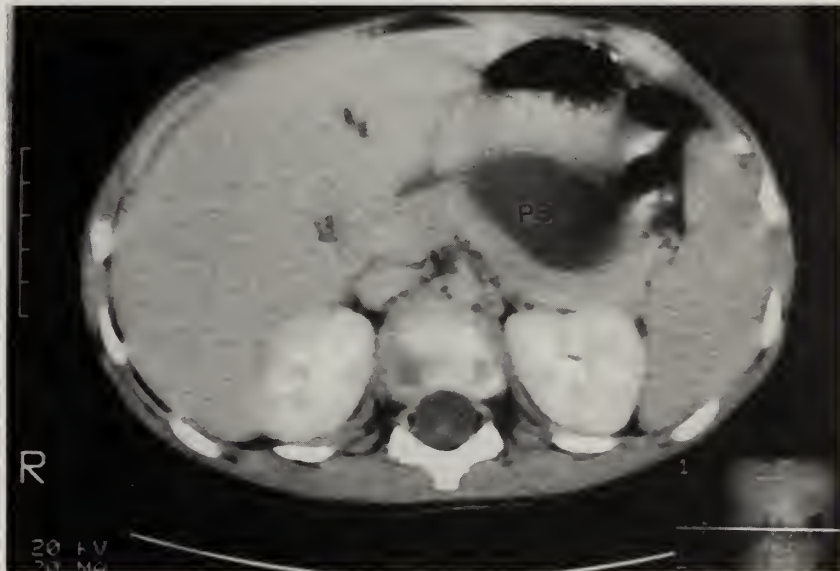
A computed tomogram 3 weeks following the injury demonstrates a pancreatic pseudocyst (PS) that is $6 \times 4 \times 5.5$ cm.
